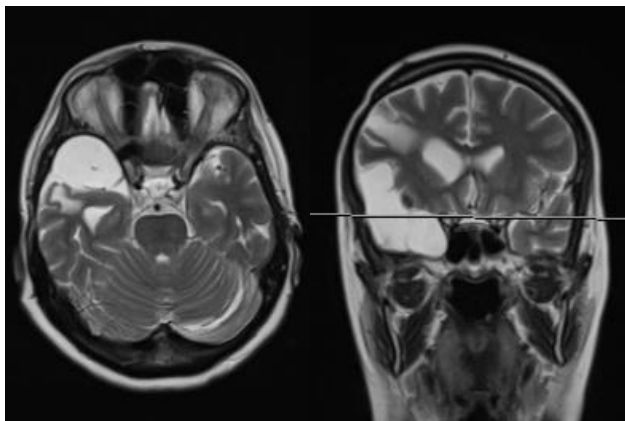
Axial (T2) and coronal (T2) non-contrast-enhanced magnetic resonance imaging (MRI) indicates refilling at the site of the prior cystic cavity one year later (Department of Radiology, Zenica Cantonal Hospital, 2020).
